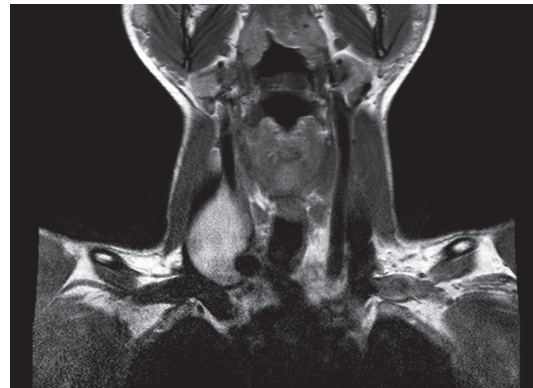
T2W coronal MRI (findings described above)
